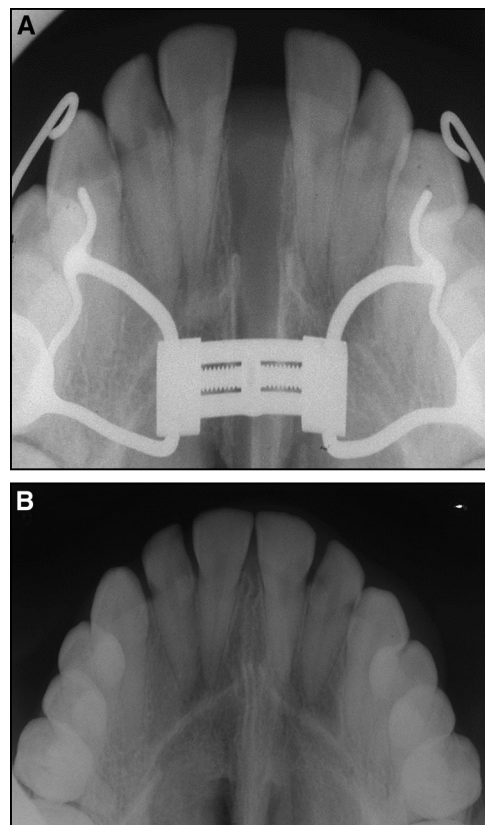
Occlusal radiographs in patient 2: A, after active RME treatment; B, 1 year from the end of active expansion therapy.
